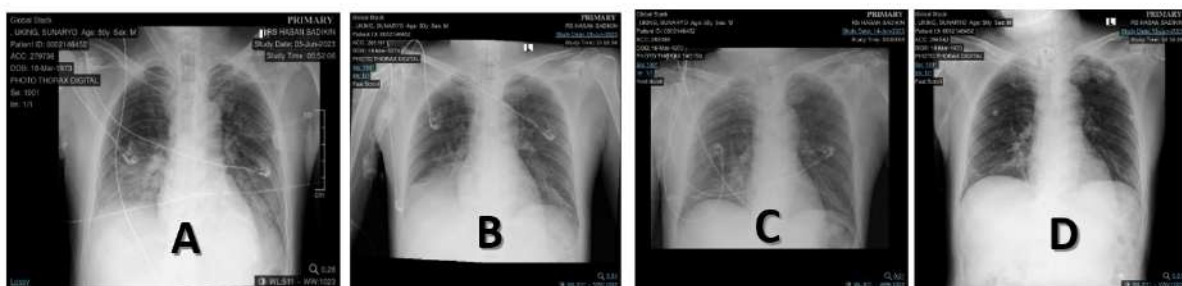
X-Ray Findings. (A) Chest X-Ray shows bilateral consolidation in both lungs (day 1). (B and C) Pneumonia improves (day 5 and day 10). (D) Complete resolution of both lungs (day 18)
